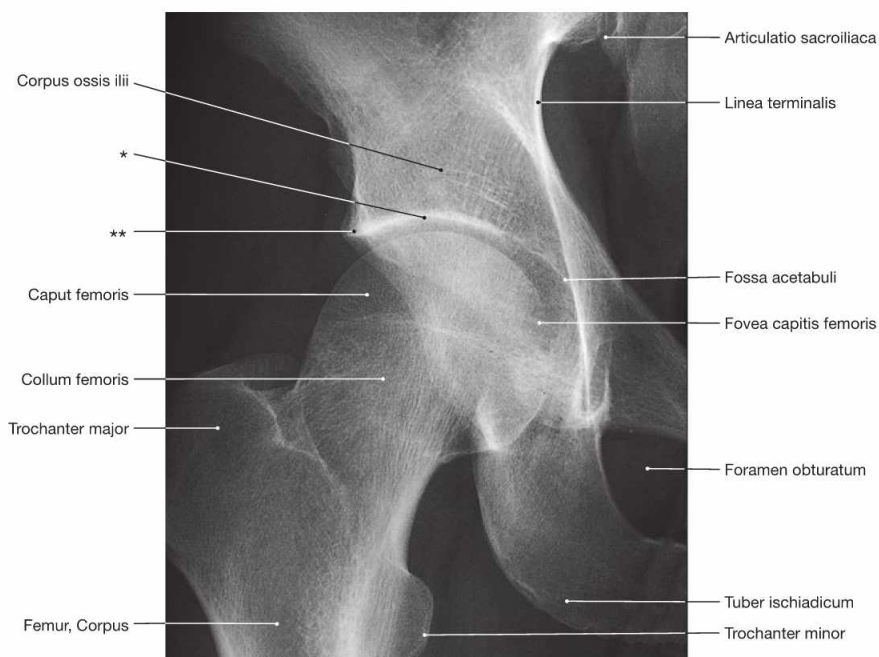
Hip joint, Articulatio coxae, right side; radiograph in anteroposterior (AP) beam projection; upright standing position.
